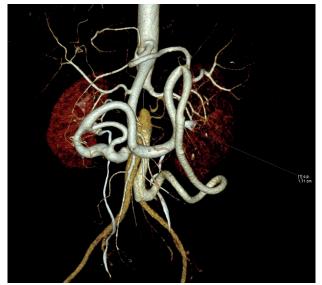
(a) Coronal 3D reconstructed volume rendered image demonstrates that the abdominal aorta shows abrupt termination at renal artery levels. Both renal arteries are normal calibration. The bifurcation level is normal. (b) Axial maximum intensity projection CT angiography image demonstrates the complete absence of aortic tissue. Only adipose tissue and lumbar collaterals are seen at that defined level.
